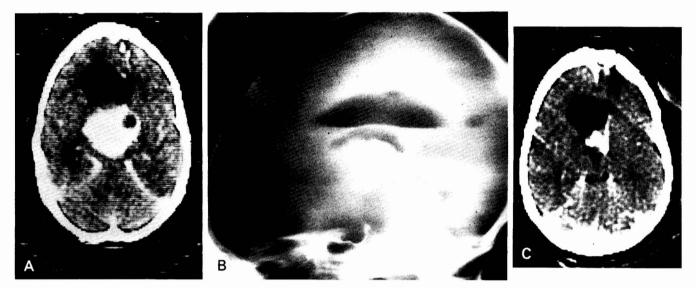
Case 1. CT scan (A) and pneumoencephalogram (B) before operation. C, residual tumor after operation. This is the only patient in this series in whom residual tumor was identified.
